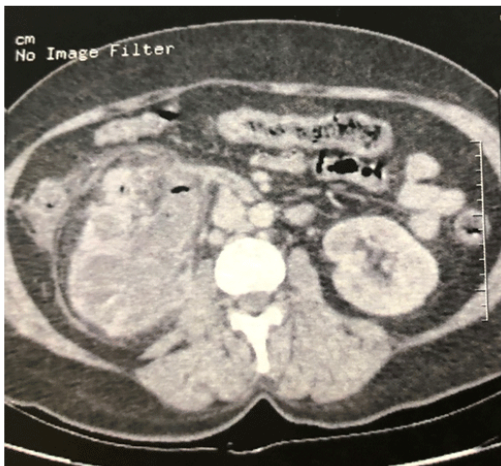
Transverse CT scan section showing renocolic fistula
